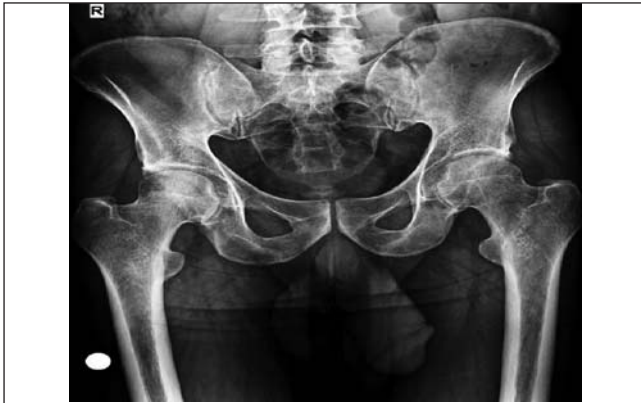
X-ray image of the patient with stage 2 avascular necrosis in the right femur head.
